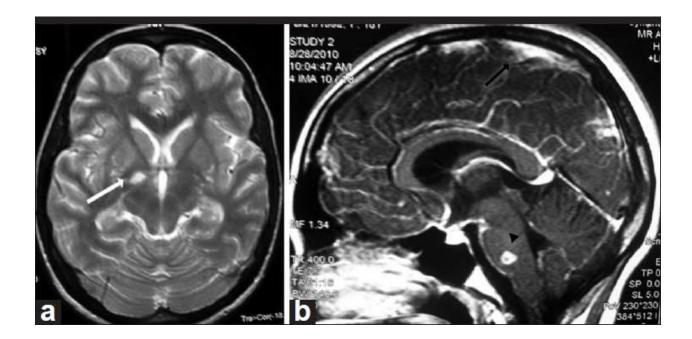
MRI Image of a patient with TBM. Figure on the left is a T2 sequence showing a right thalamic infarct (white arrow). Figure on the right is a post Gandolinium contrast T2 FLAIR sequence showing meningeal enhancement in the parietal , occipital lobe surfaces (black arrow) and a tuberculoma (seen a ring lesion)in the pontine region (black arrowhead). This image demonstrates the multiple findings seen in TBM.
